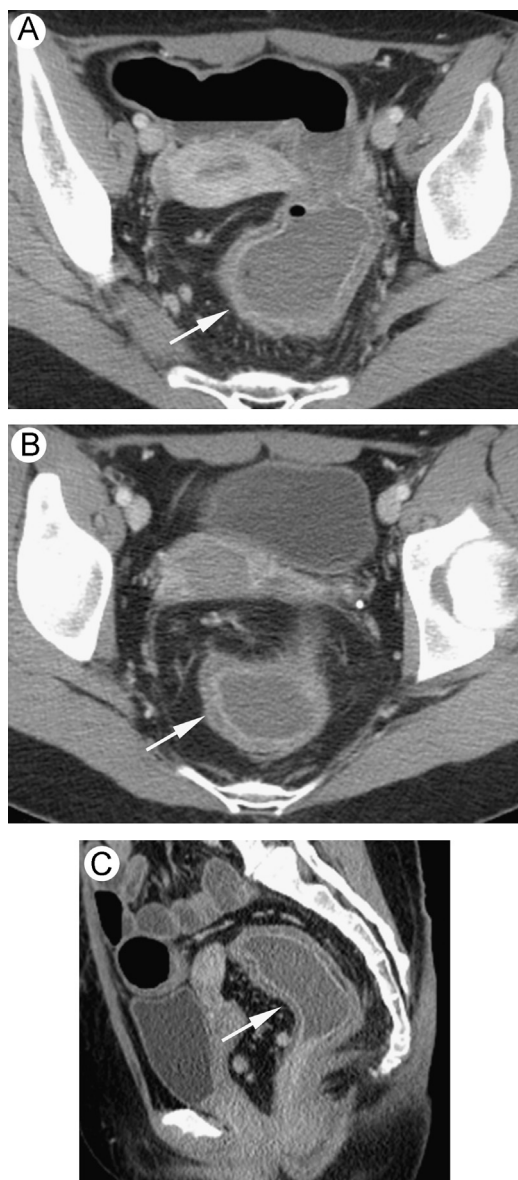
Axial (A), coronal (B), and sagittal (C) CT images demonstrate mucosal hyperenhancement and bowel-wall thickening of the ileum and J pouch (arrows), including a targetoid appearance suggesting submucosal edema, consistent with pouchitis.
